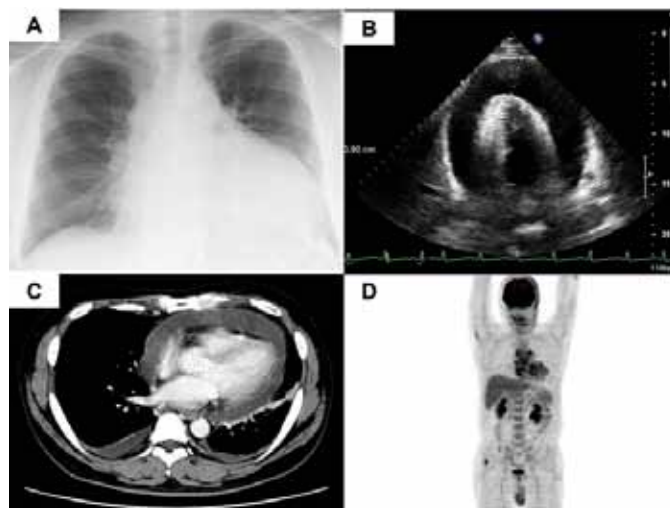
(A) Chest radiograph, at the time of admission, showing cardiac enlargement, (B) Two-dimensional echocardiogram showing large pericardial effusion with tamponade physiology, (C) Axial computed tomography section through the chest after intravenous contrast, mediastinal window showing a massive pericardial effusion without any evidence of intracardiac abnormality, and (D) ¹⁸F-labeled deoxyglucose (FDG) positron emission tomography scan, showing increased FDG uptake in mediastinum nodules, pericardium, gluteus medius muscle, and cervical vertebrae.
